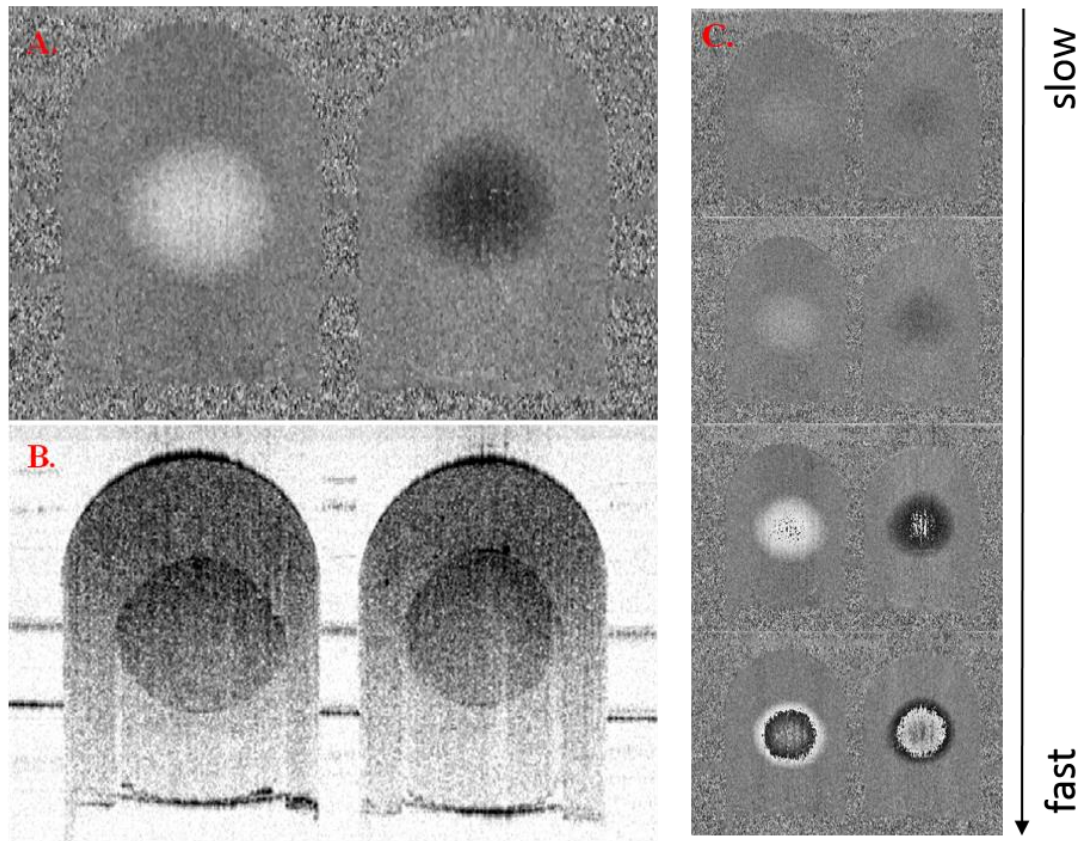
Doppler flow images of a U-shaped tube with Intralipid perfusion. A. Bi-directional flow is demonstrated as the white and black circles, and the gray shells surrounding them are the tube. B. The corresponding reflectivity image. C. Multiple flow images are shown with different velocities. Flow speed is increasing from top to bottom. The external diameter of the tube is 1 mm.
